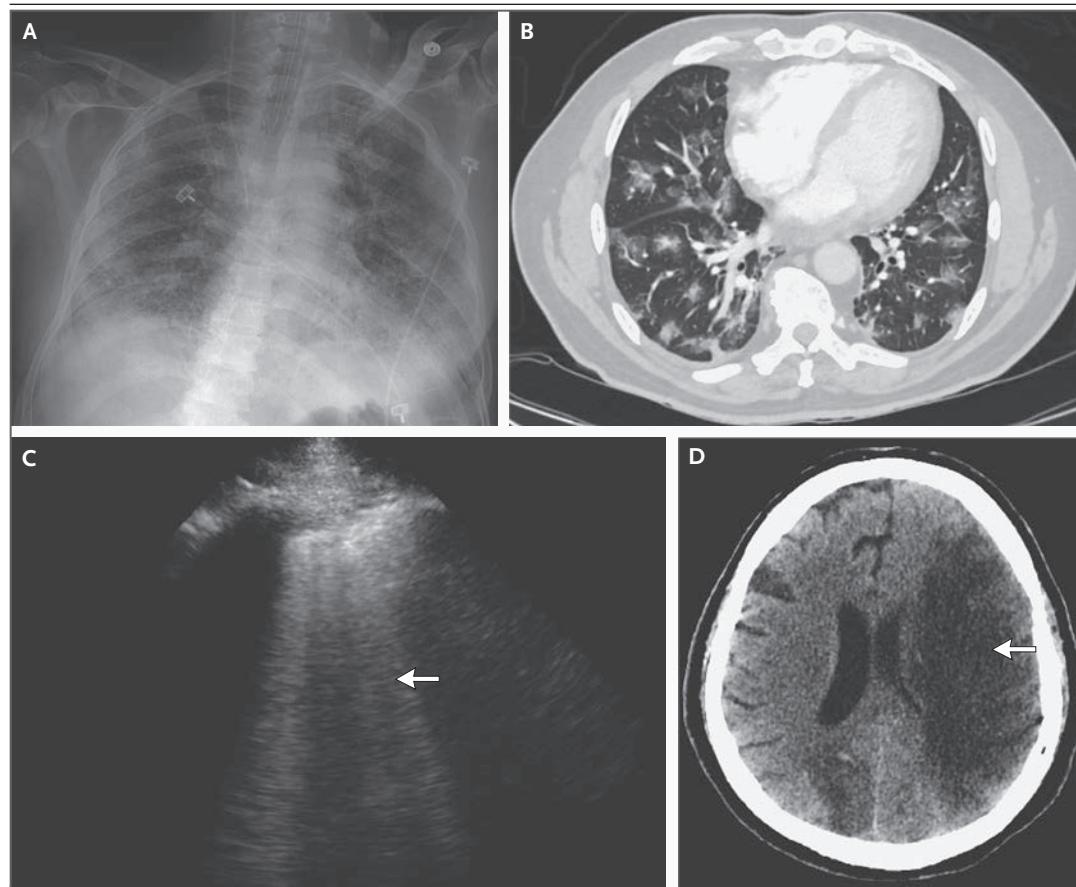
Radiographic and Ultrasonographic Findings of Severe Covid-19. Chest radiography (Panel A) shows bilateral ground-glass opacities and consolidations. Computed tomography (CT) of the chest (Panel B) shows bilateral ground-glass opacities. Thoracic ultrasonography (Panel C) shows B lines (arrow); this image is courtesy of Dr. Christopher Parkhurst. CT of the head (Panel D) shows left-greater-than-right cerebral infarcts (arrow).
